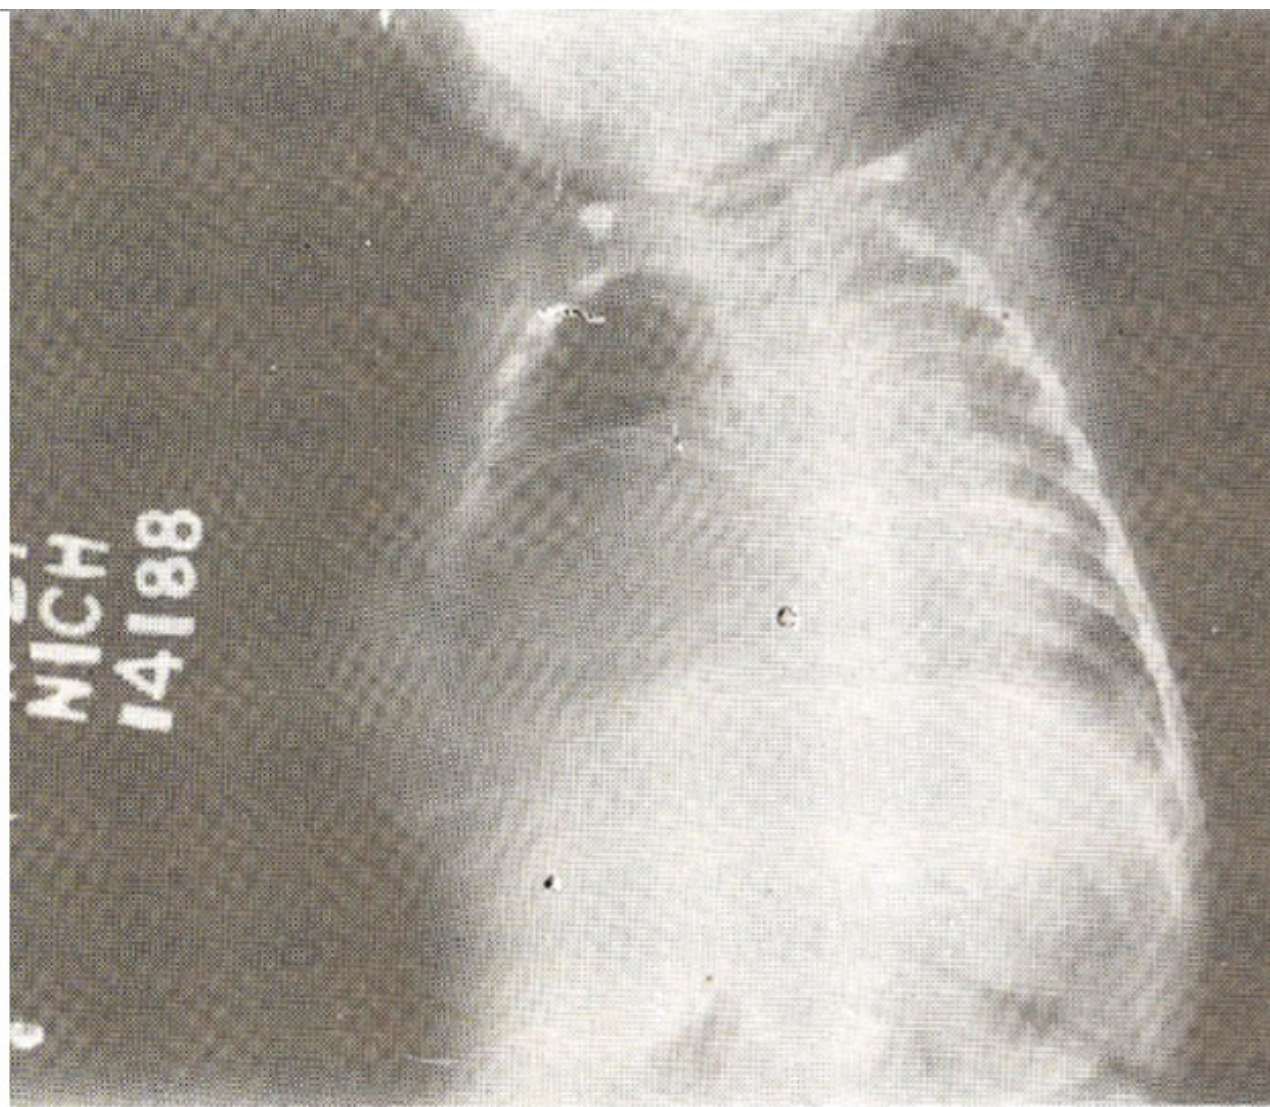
Chest x-ray showing a large soft tissue mass with irregular calcification in the right side of the chest. It is causing deformity of ribs (7th through 10th) with associated scoliosis of dorsal spine.
